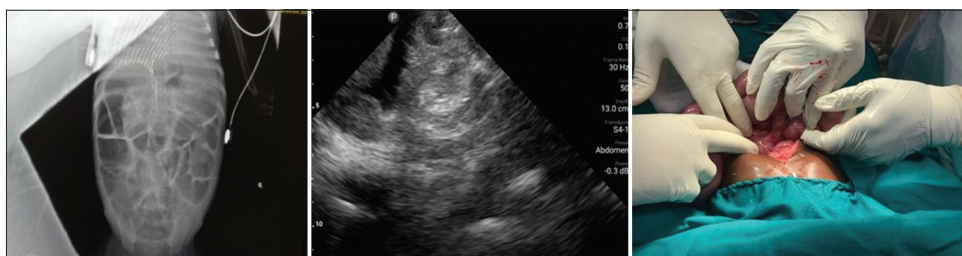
X-ray, ultrasound, and intraoperative findings of case 1
